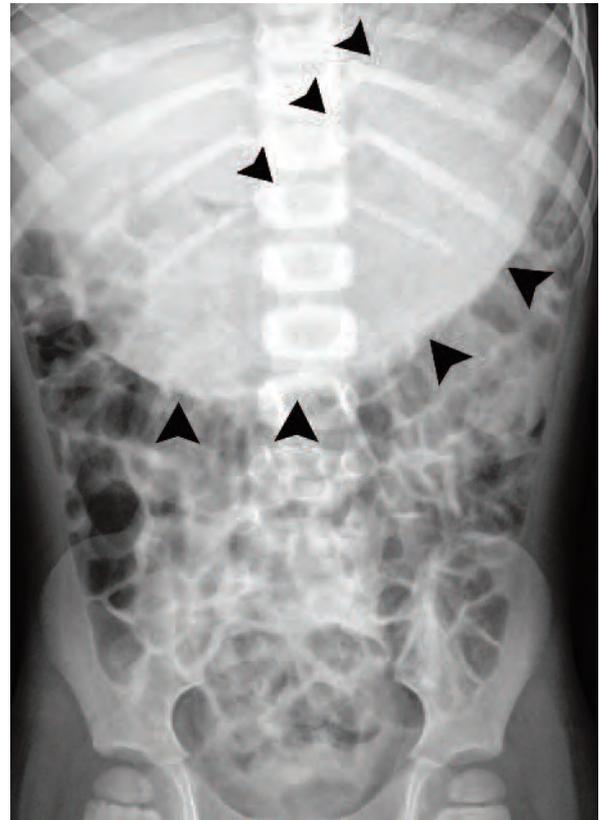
Initial flat-plate abdominal radiograph demonstrating gas-filled small and large bowel loops but opacification of the gastric silhouette (arrowheads).
